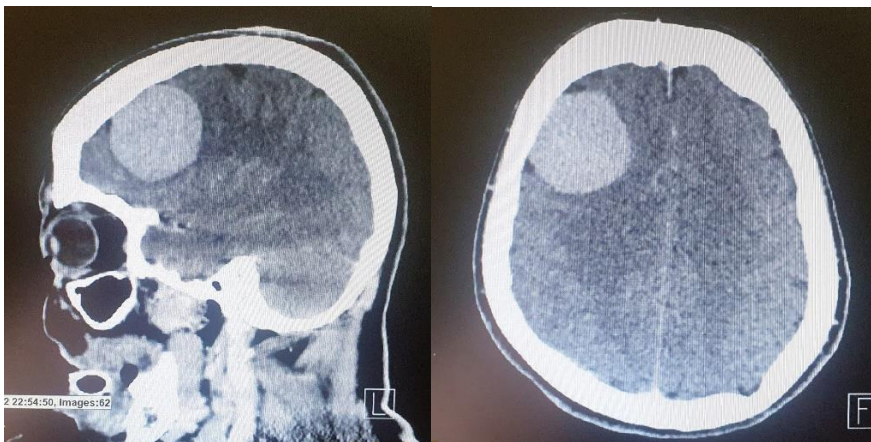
CT brain with angiography.
